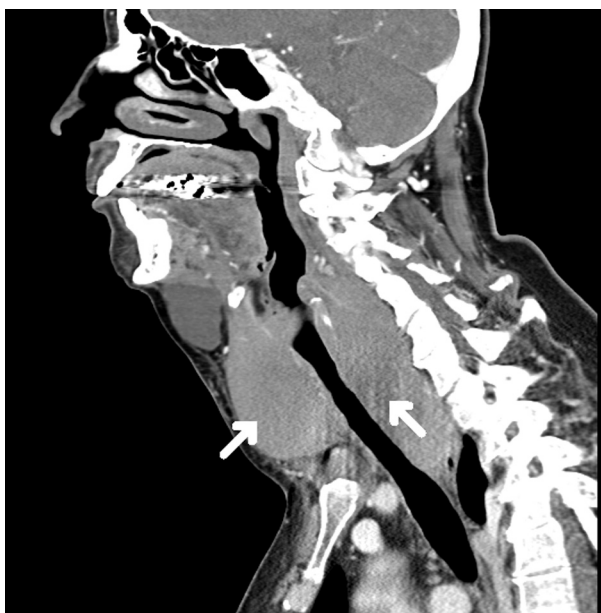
CT of the neck with intravenous contrast (sagittal view), demonstrating a neck mass with laryngeal displacement (arrows).
